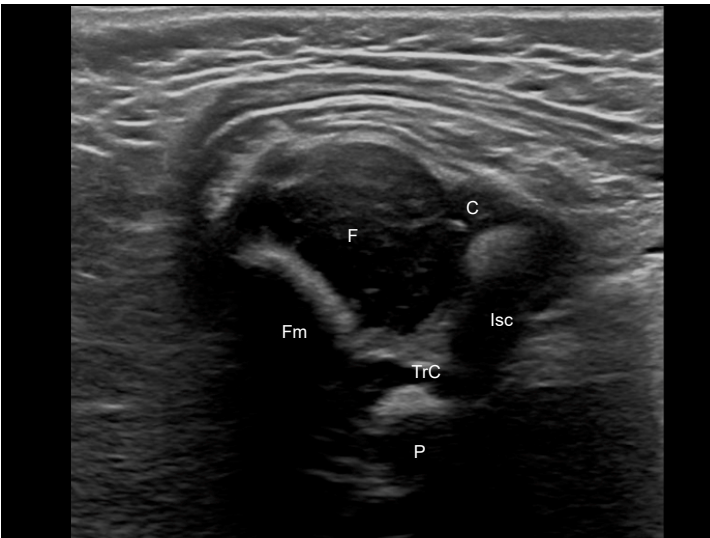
Labeled Transverse ultrasound image
